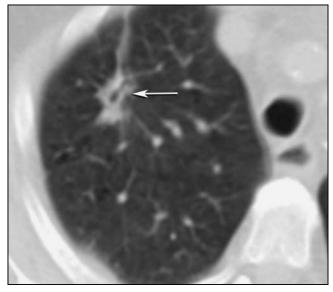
CT lung windows shows a stable ablation scar five years following MWA.
